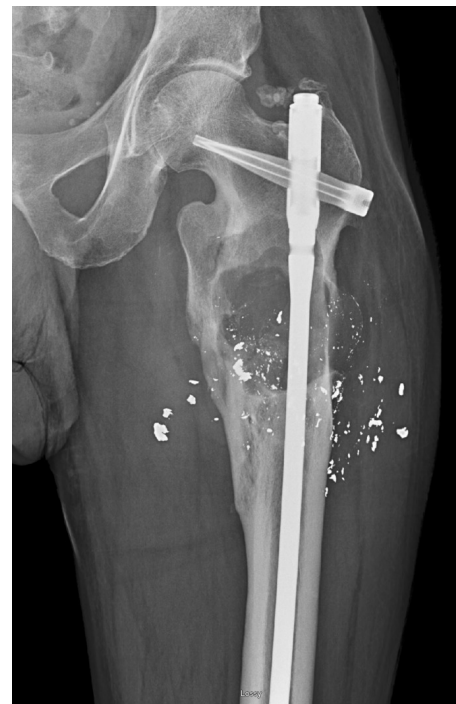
Radiograph of the left femur, demonstrating a cephalomedullary nail *in situ*, bullet fragments, and a remote subtrochanteric femur fracture with lytic changes
